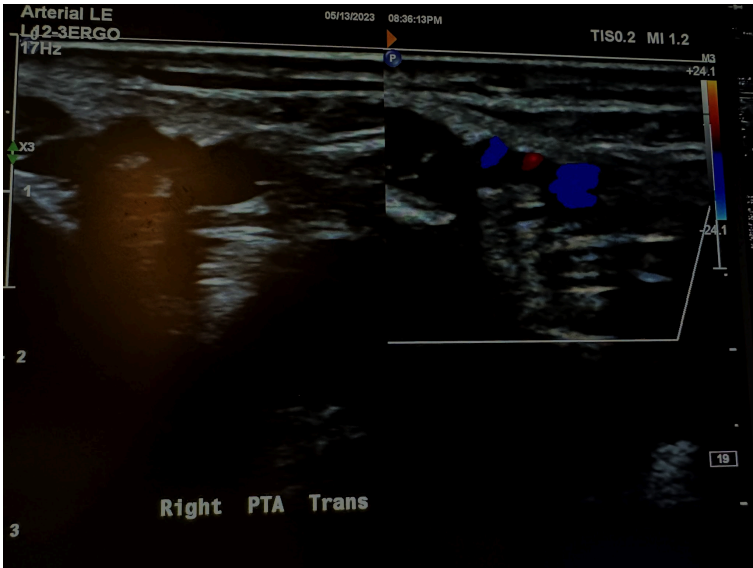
Side-by-side transverse images of the right posterior tibial artery without color Doppler and with color Doppler.
